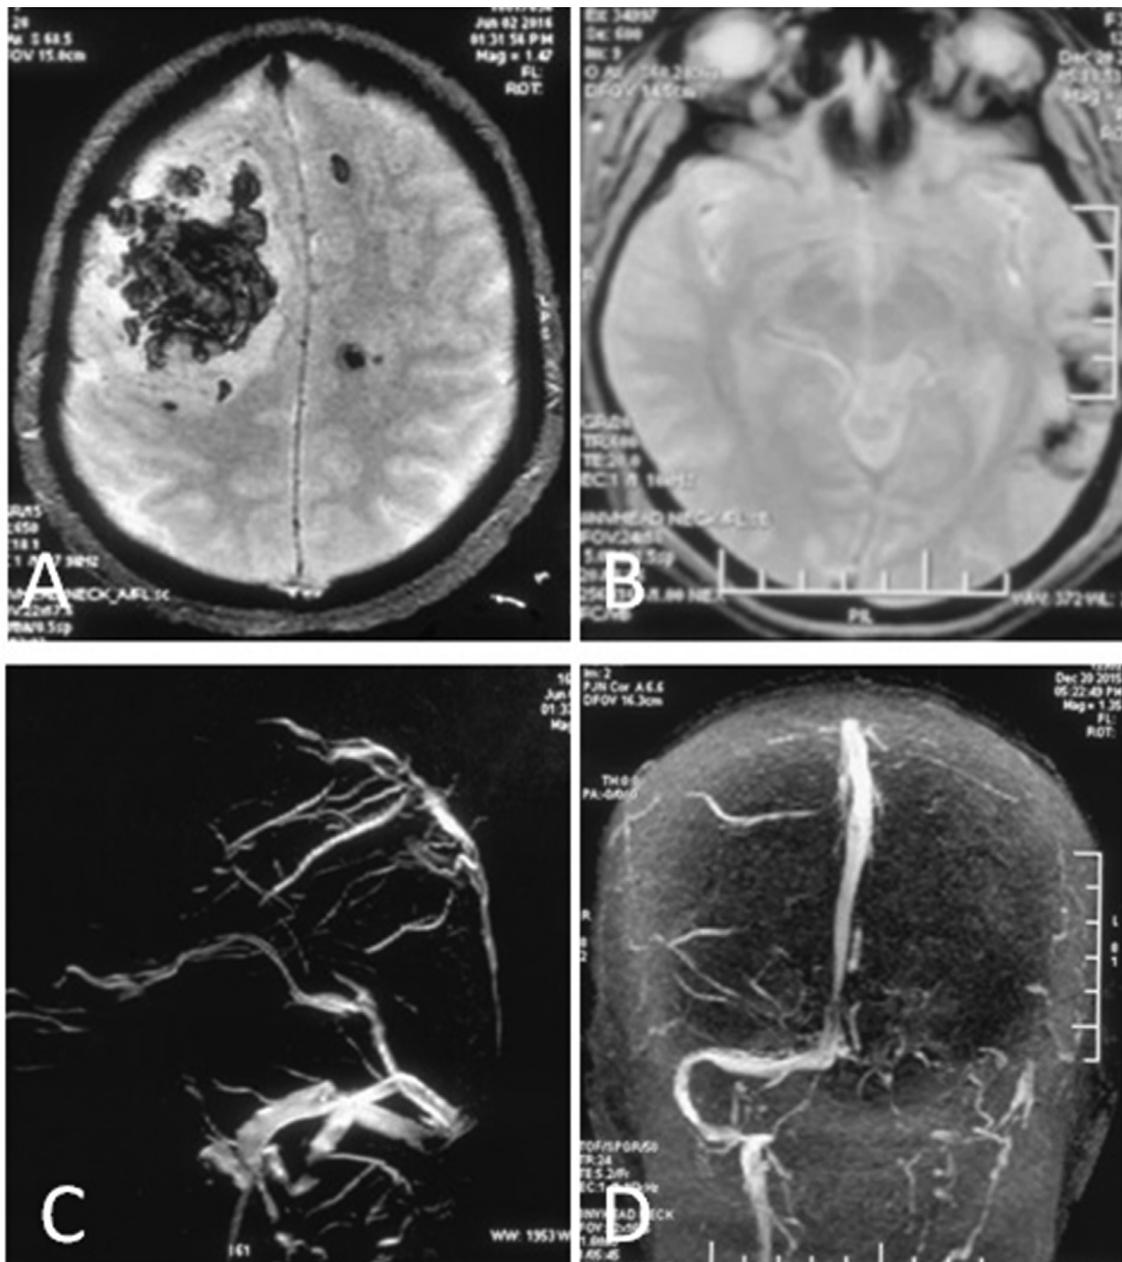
MRI in susceptibility weighted sequence and MRV showing location of parenchymal lesion and site of venous sinus thrombosis. (A) MRI of a male patient shows hemorrhagic infarction in both frontal lobes, predominantly on the right with (C) thrombosis of anterior half of superior sagittal sinus. (B) MRI of a female patient shows left temporal hemorrhagic infarct with (D) left transverse and sigmoid sinus thrombosis.
